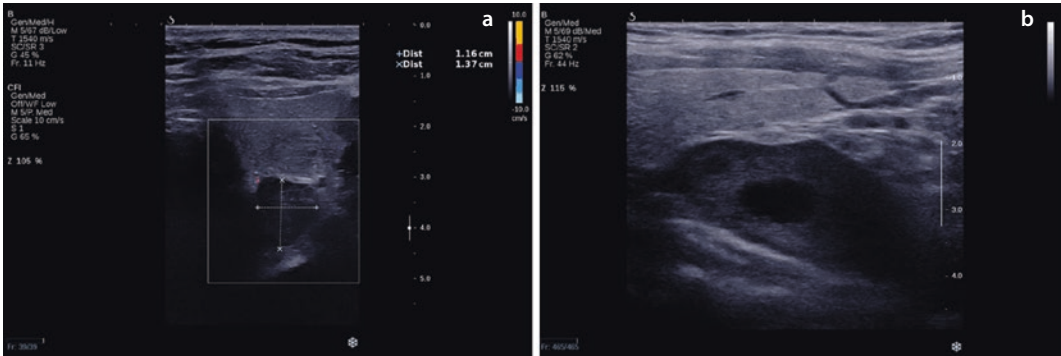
Neck ultrasound (axial a and longitudinal b images)—a large well-defined hypoechoic mass posterior-inferior to the left lobe of the thyroid gland is visible
